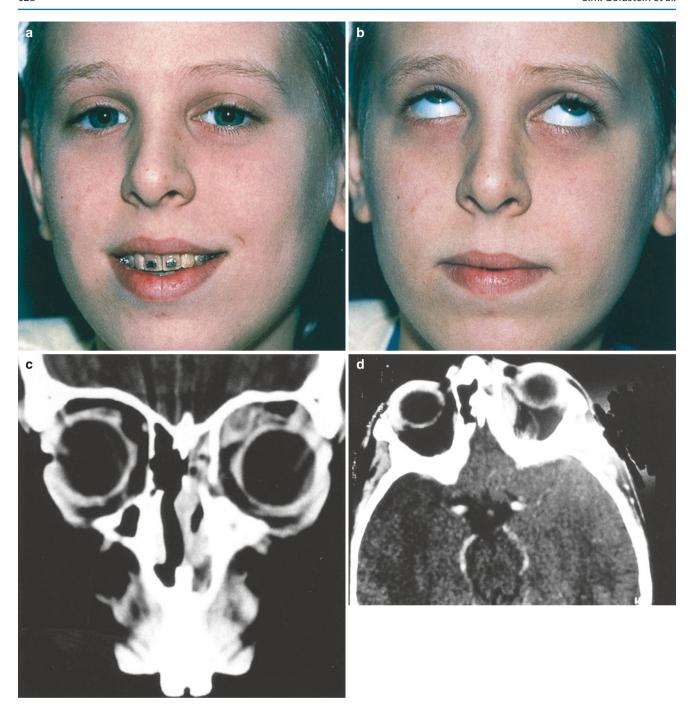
Subperiosteal effusion. (a) This 11-year-old patient presented with a complaint of double vision. (b) The alteration in motility is seen in upgaze. (c) The coronal CT scan demonstrates his left-sided
